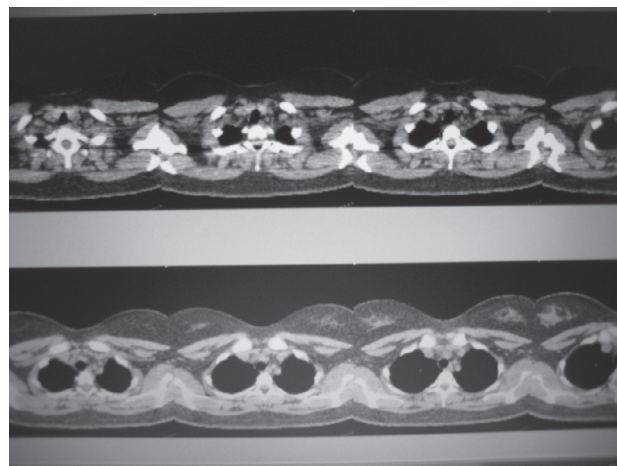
CT scan images.
